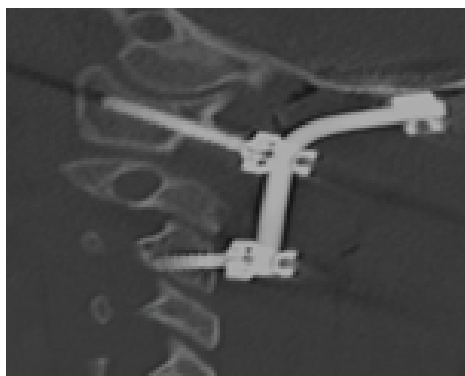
Sagittal CT of the cervical spine demonstrating the post-operative occipital-cervical construct.
